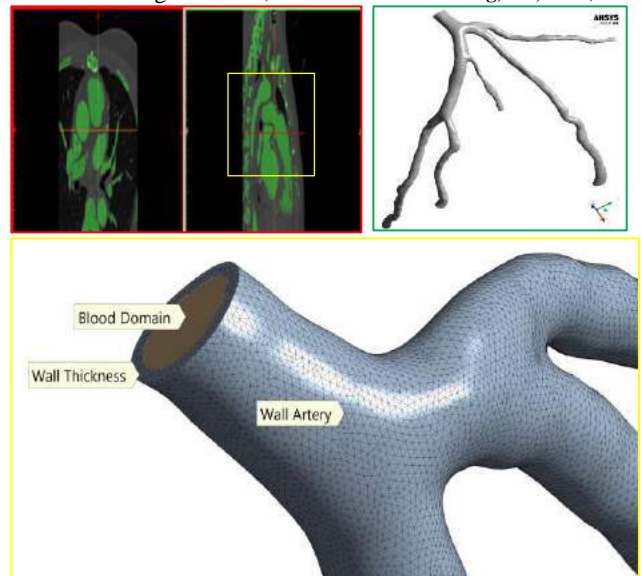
a) 2D CT-Scanned data in MIMICS window (Red outline); b) .stl format reconstructed LCA 3D-model (Green outline)
